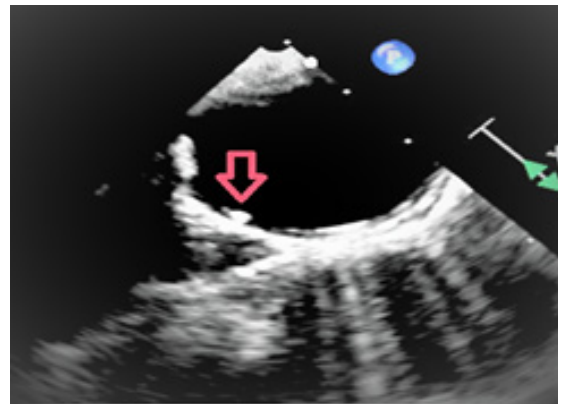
Transesophageal echocardiogram, Red arrow shows a grade III atherosclerotic changes of descending aorta.
